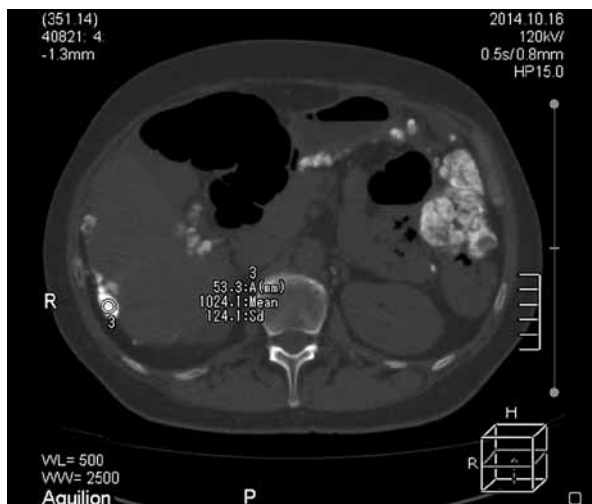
Computed tomography scan of the abdomen without contrast media supply. Transverse scans of the abdomen with visible massive calcifications
